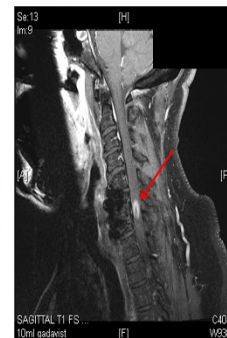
Sagittal T1 MRI image of cervical ependymoma in our patient. The mass is located at precisely the level of neck manipulation for intubation.
